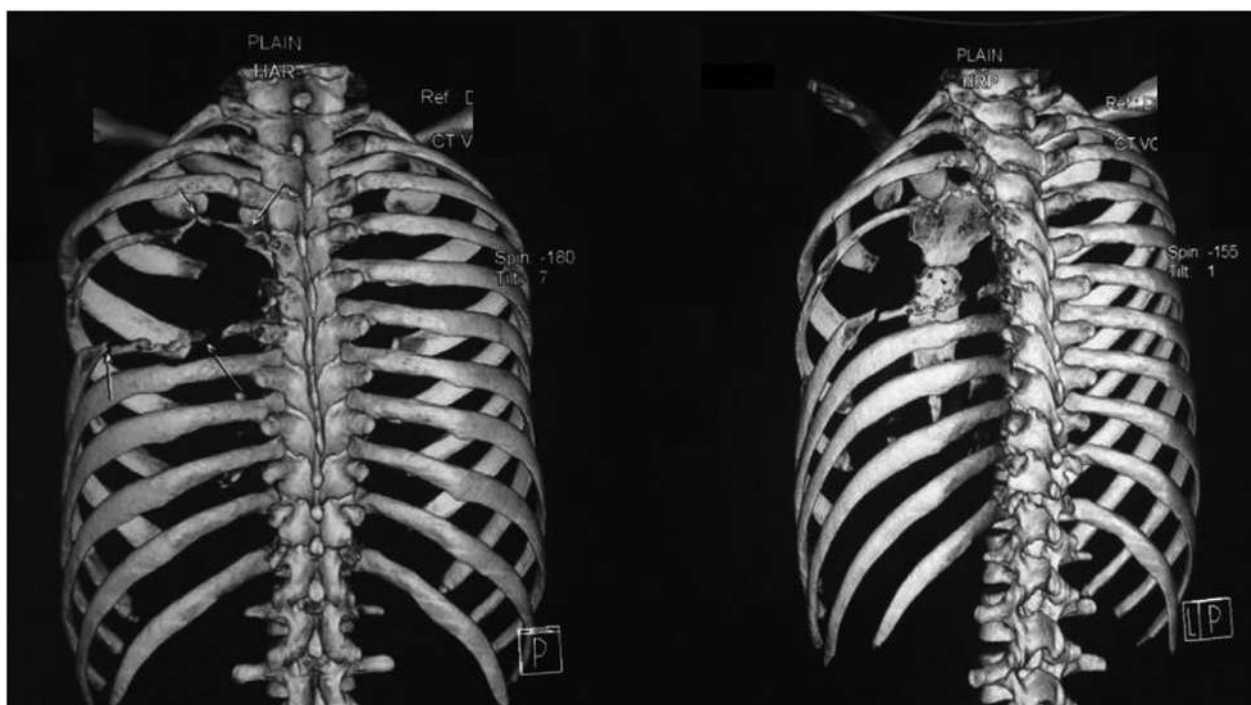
A reconstructed computed tomography scan showed lytic destruction of the fourth to sixth ribs in the left hemithorax.
